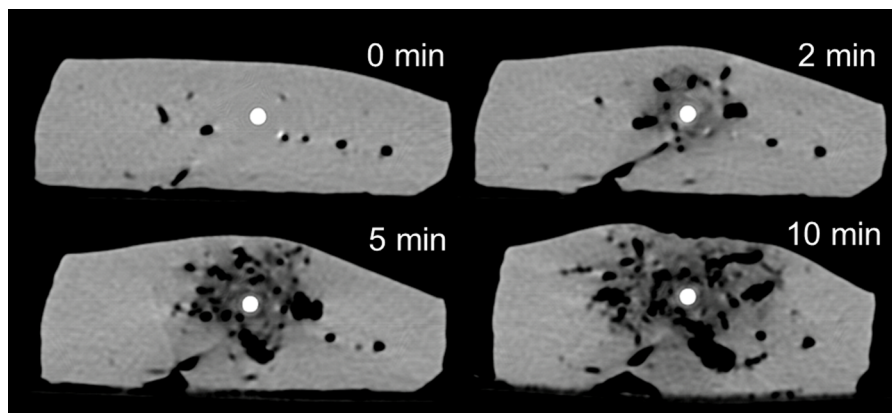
Axial CT images acquired 0, 2, 5, and 10 min during microwave ablation. Vapor generated around the antenna is notable, with growth and diffusion from central (around the antenna) to peripheral regions (distant from the antenna).
